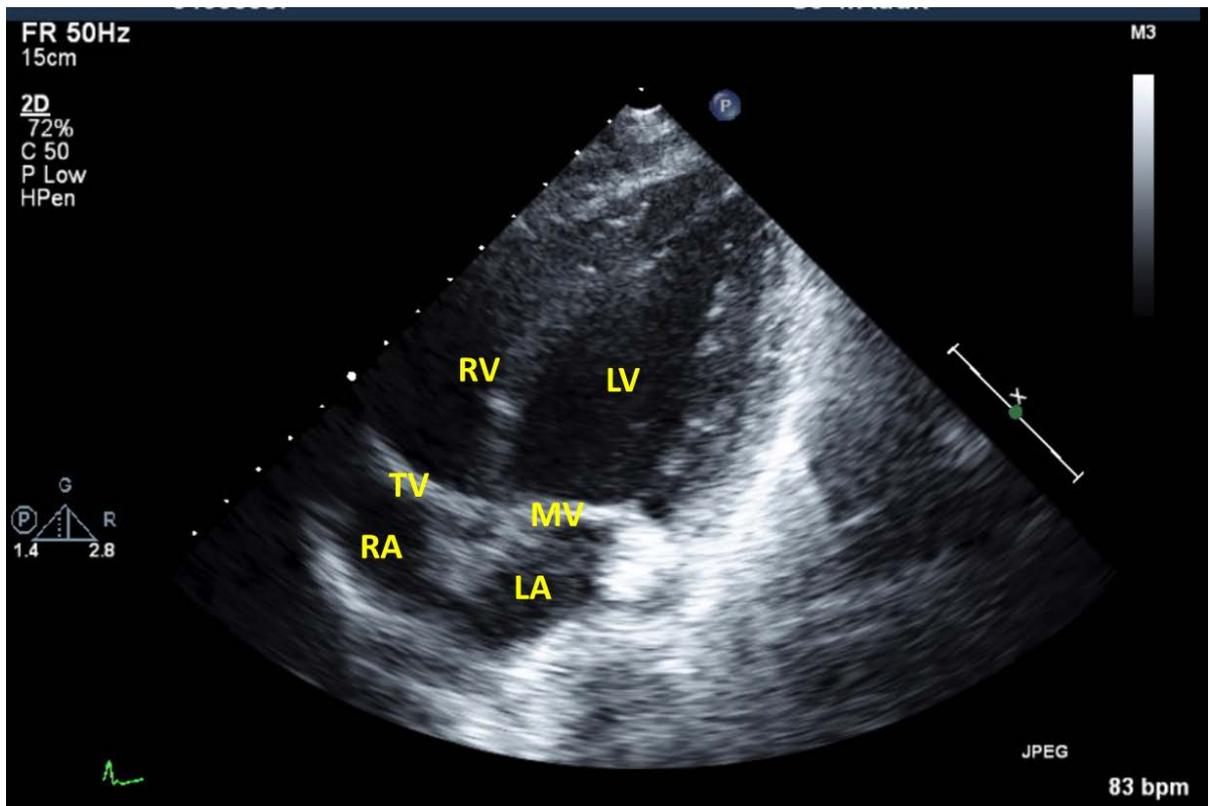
Apical four chamber view
